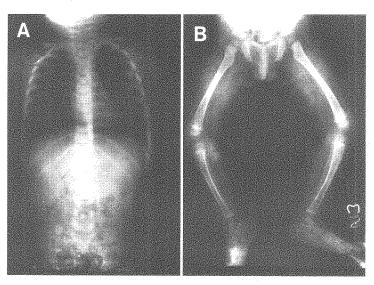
Photograph of the X-ray plate A) Showing normal spine and chest of the child. B) Showing normal pelvic and lower limb bones.
